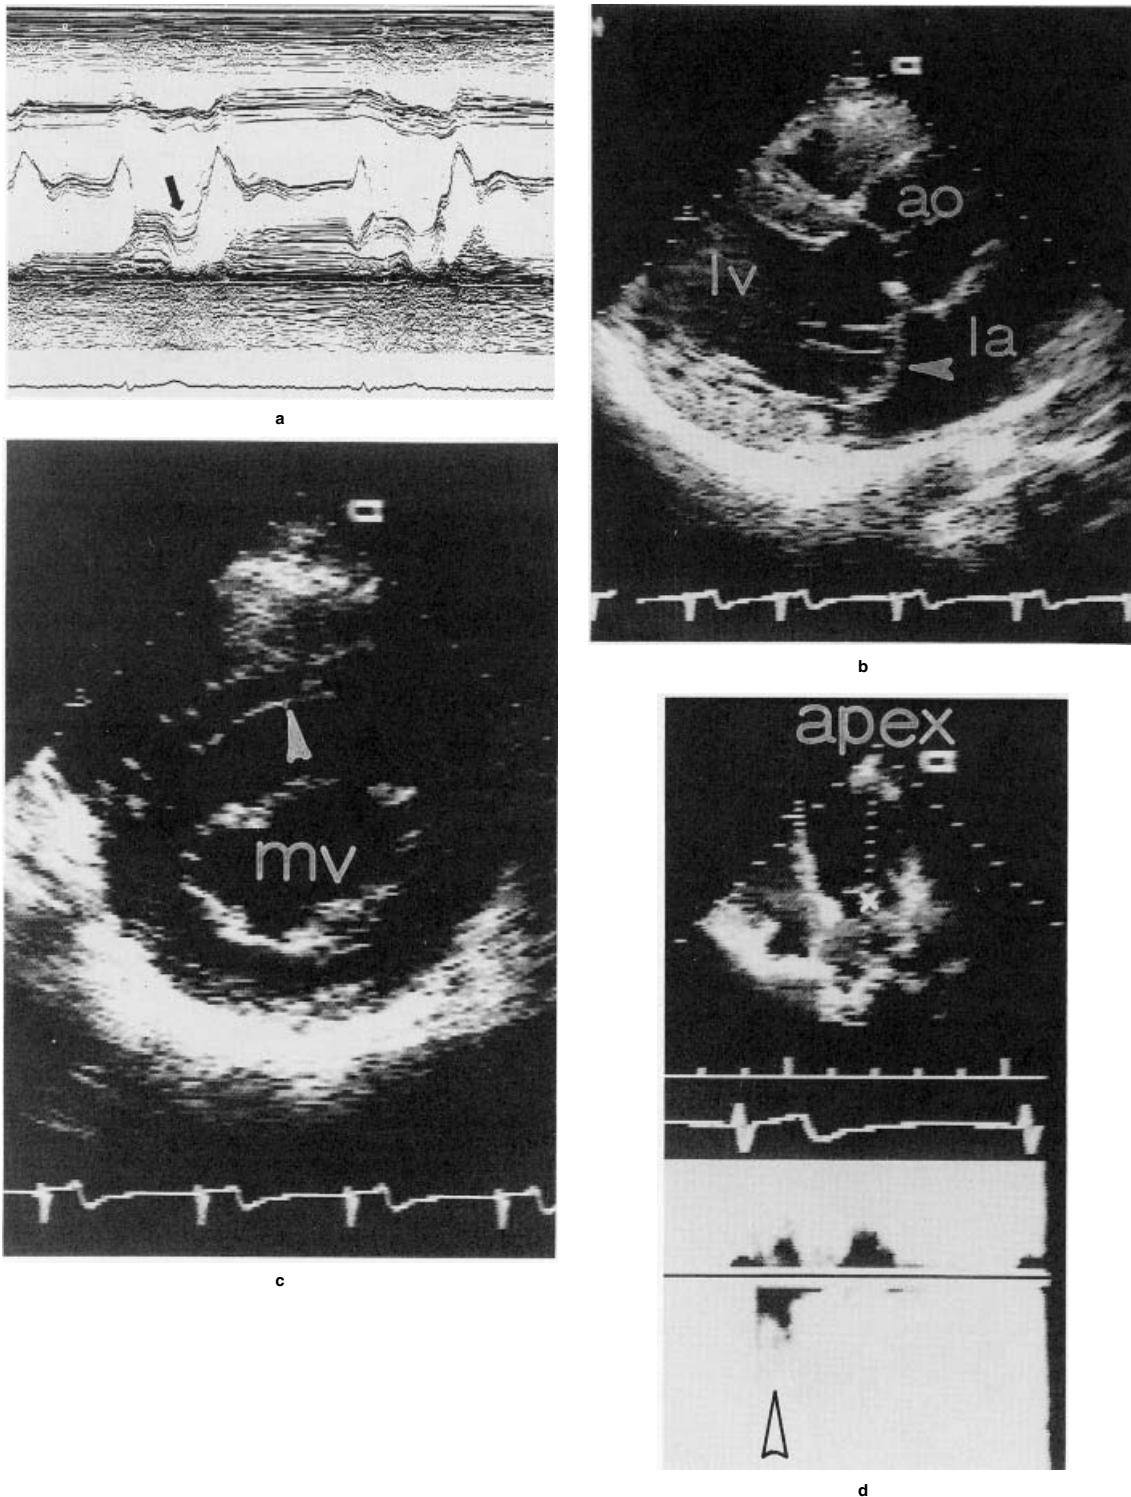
The mitral valve in Marfan syndrome as viewed by echocardiography. a: A one-dimensional (M-mode) tracing; the arrow points to the mid-systolic prolapse. b: A cross-sectional (two-dimensional) scan in the parasternal long-axis view; the arrowhead points to the prolapsing mitral leaflets. la, left atrium; lv, left ventricle; ao, aortic root. c: A cross-sectional parasternal short-axis view of the left ventricle. The letters "mv" are surrounded by the patulous mitral leaflets, open in diastole. The arrowhead points to the left ventricular endocardium. d: Pulsed-wave Doppler examination of the mitral valve. The upper part of the figure shows a cross-sectional echocardiogram in the apical four-chamber view; the "x" marks the sampling space for Doppler interrogation and is located just to the atrial side of the mitral valve. The lower part of the figure shows the Doppler tracing, with the arrowhead pointing to turbulent flow away from the sampling space (downward in the figure) in systole, indicative of mitral regurgitation.
